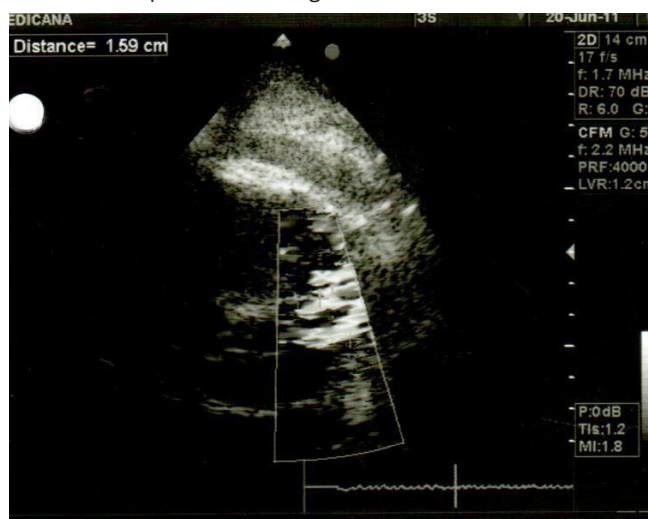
Echocardiography showed that turbulent flow from the fistula between the aorta and the pulmonary artery.
